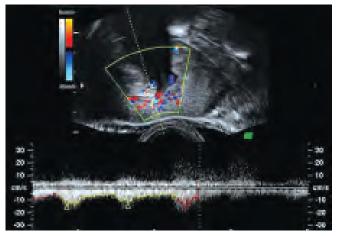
Color Doppler following saline infusion sonography. Note moderate vascular impedance
